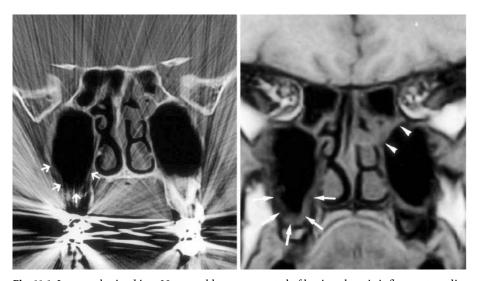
Images obtained in a 38-year-old man suspected of having chronic inflammatory disease of the maxillary sinus. (*Left*) CT scan shows extreme artifacts from dental work. Mucosal thickening (*arrows*) in the right maxillary sinus can easily be missed. Evaluation of the frontal lobe and the orbital tissues is almost impossible, even if a soft-tissue window were used. Partial opacification of the ethmoid cells is present. (*Right*) MR image (60/12; flip angle, 40°) depicts mucosal thickening (*arrows*) in the right maxillary sinus without artifact. The frontal lobe and orbits can be evaluated very well. Soft-tissue signal intensity in the ethmoid cells (*arrowheads*) is present. Reprinted with permission from Hahnel S, Ertl-Wagner B, Tasman AJ, Forsting M, Jansen O. Relative value of MR imaging as compared with CT in the diagnosis of inflammatory paranasal sinus disease. Radiology 1999; 210:171–176
